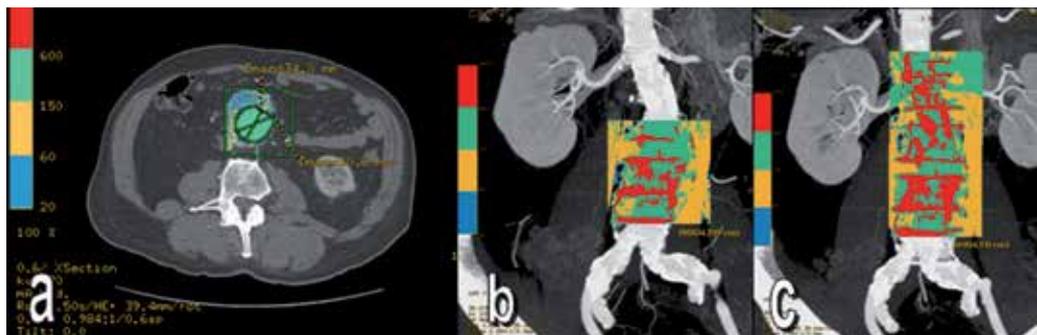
MD CT volumetric measurement of infrarenal aorta and aa.iliace comm bill in patients with calcium channel intraluminal nodular induration (a,b) patients with AAA and without calcium induration in the wall (c,d).
